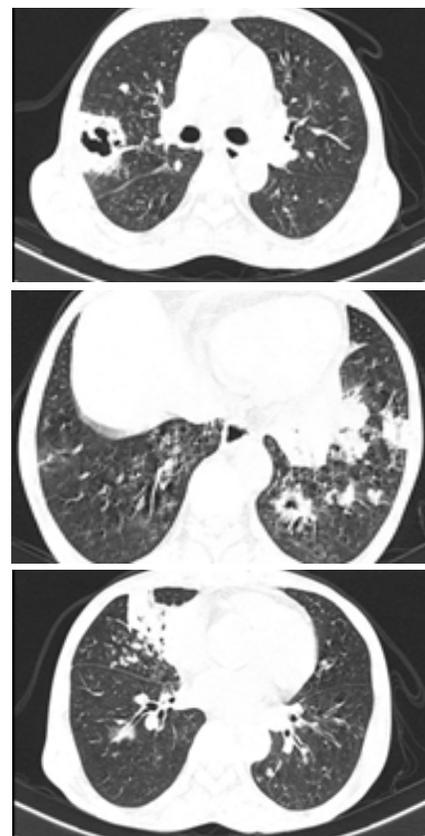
CT Chest showing cavitary pneumonia
